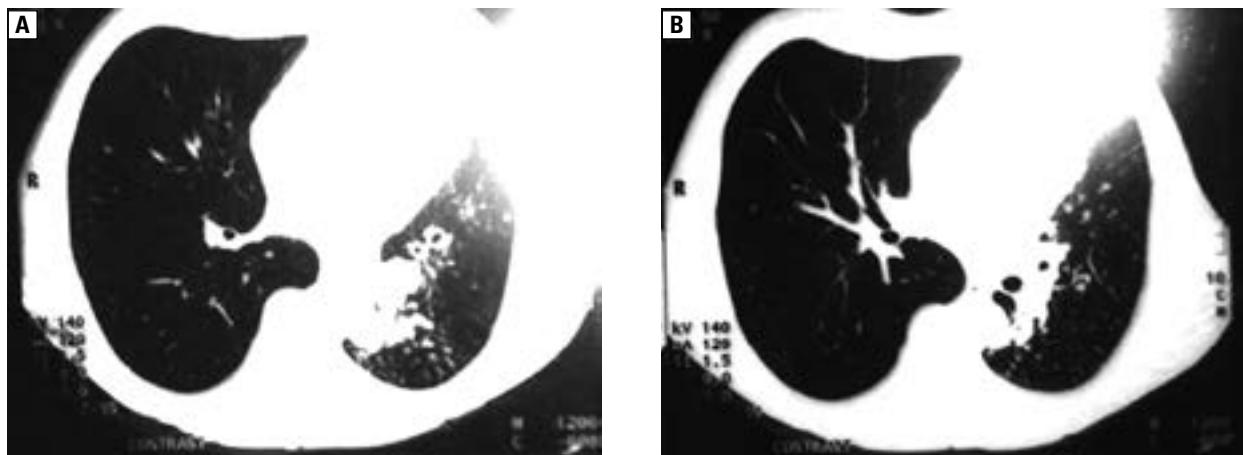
High resolution computed tomography of the lung of patient in Case 2 showing bronchiectasis and mucus plugging
